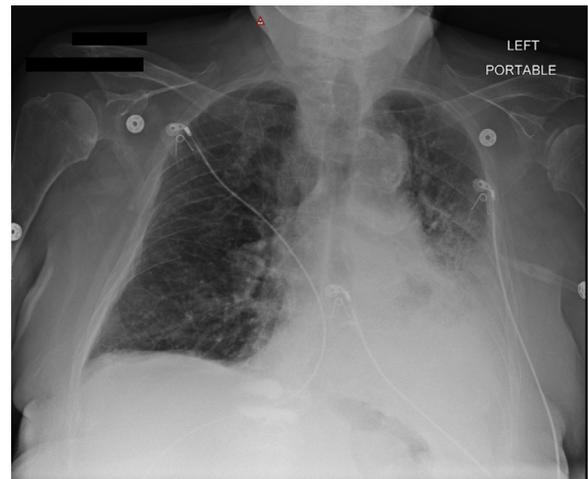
Chest radiography demonstrating opacification of the lower left hemithorax, suggesting the presence of pleural effusion.
